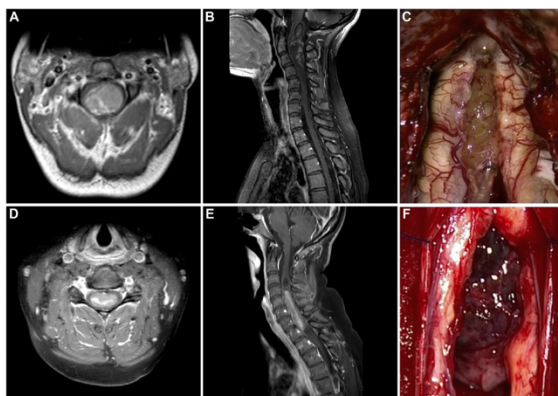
Sagittal (A) and axial (B) T1-weighted gadolinium-enhanced magnetic resonance imaging and intraoperative picture (C) of a surfacing tumor, defined as an intramedullary eccentric tumor reaching the cord surface; sagittal (D) and axial (E) T1-weighted gadolinium-enhanced magnetic resonance imaging and intraoperative picture (F) of a centromedullary tumor, defined as a tumor located in the middle of the cord and surrounded by normal parenchyma.
